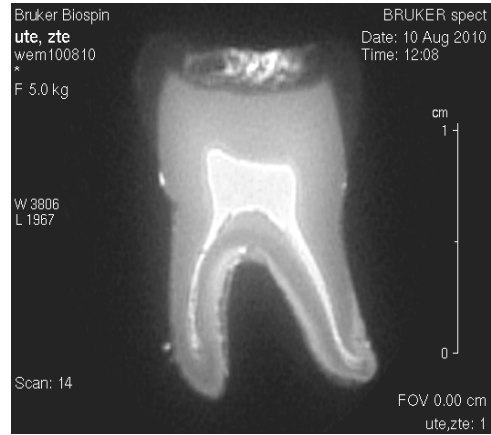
Image of an extracted human tooth obtained with hard-pulse Zero-TE MRI at 11.7 T
